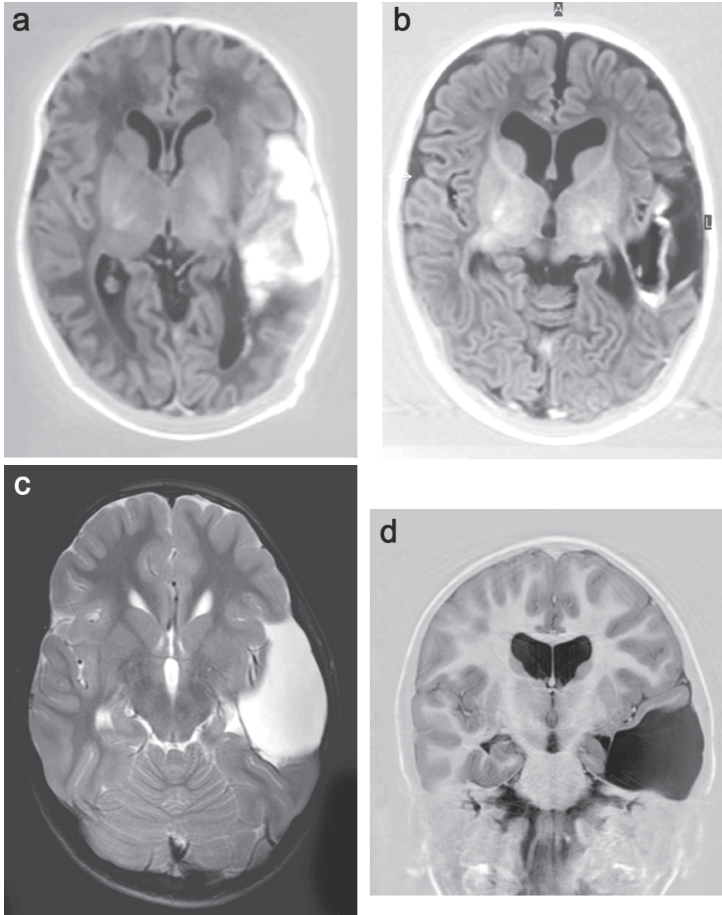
MRI, IR (a,b), and T2 spin echo (c) axial views obtained on day 10, at 3 months and at 7 years and coronal IR (d) obtained at 7 years. A large hemorrhage in the temporal lobe is seen in the neonatal period (a) with cystic evolution at 3 months (b). End stage of the lesion showing complete destruction of the left temporal lobe can be appreciated at 7 years (c,d). Outcome is complicated by behavioral problems (tics and hyperactivity).
